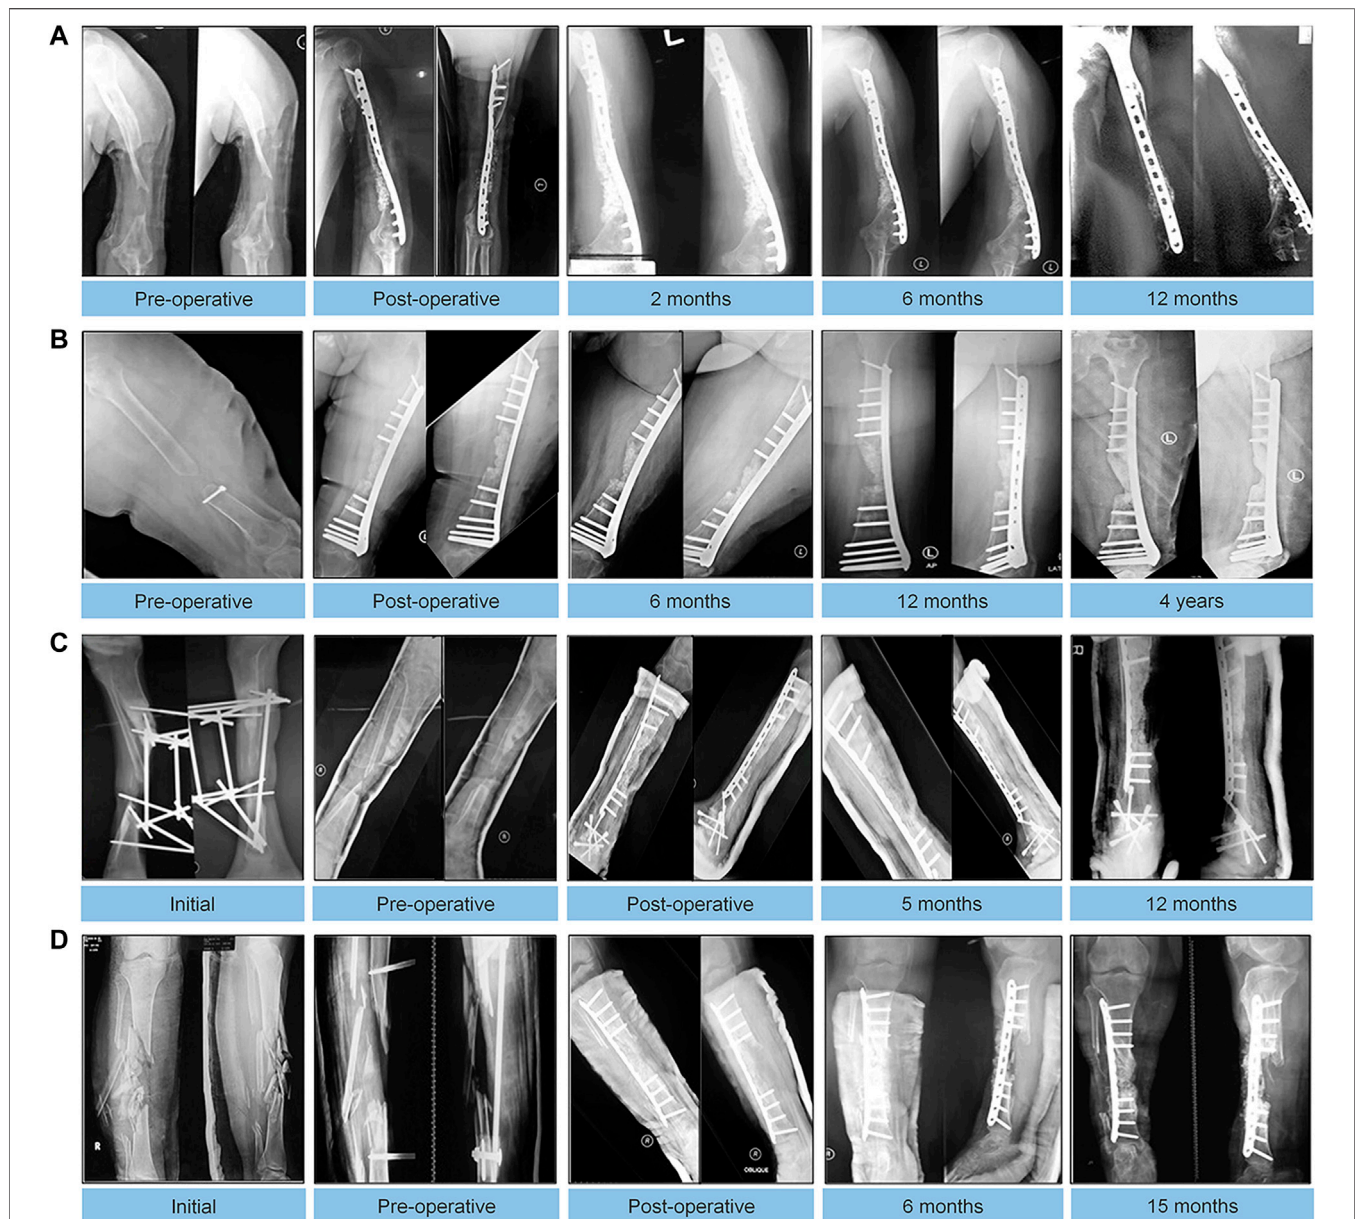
Autologous MSC implantation, hydroxyapatite, BMP-2, and internal fixation for treating critical-sized defects. Radiographic results of follow-up visits of 4 cases. (A): An 18-year-old male with 5-cm bone defect of the humerus. (B): An 18-year-old male with 5-cm bone defect of the humerus. (C): A 28-year-old male with 7-year history of 8-cm bone defect of the right tibia. (D): A 24-year-old female with 12 cm bone defect of the tibia. Reprinted with permission from (Dilogo et al., 2019).
